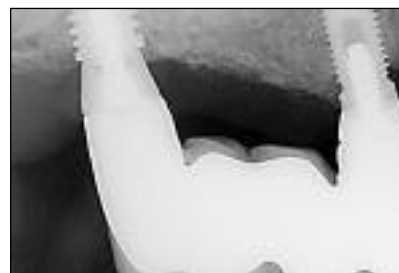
Standardized radiograph after 12 months in function. Note the difference in crestal bone loss around both types of implants.
